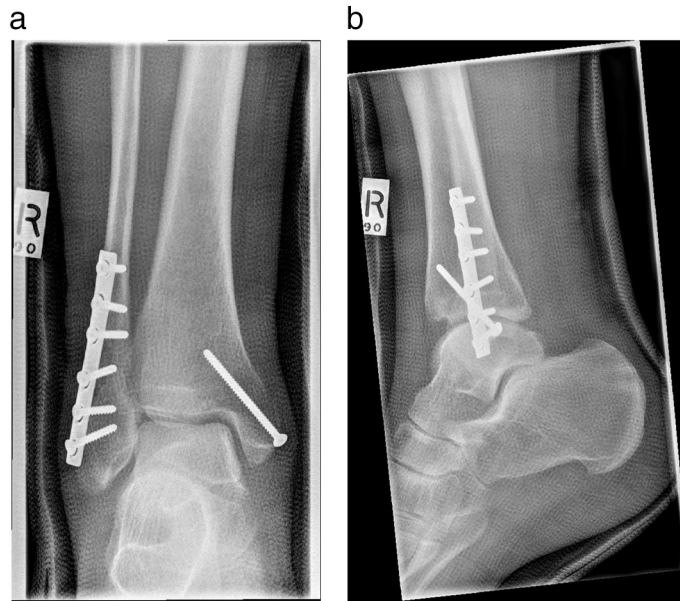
a: Anteroposterior radiograph of the right ankle dated 21 August 2006 showing internal fixation of the lateral malleolar fracture with an interfragmentary screw and a six hole plate and of the medial malleolar fracture with one screw.
